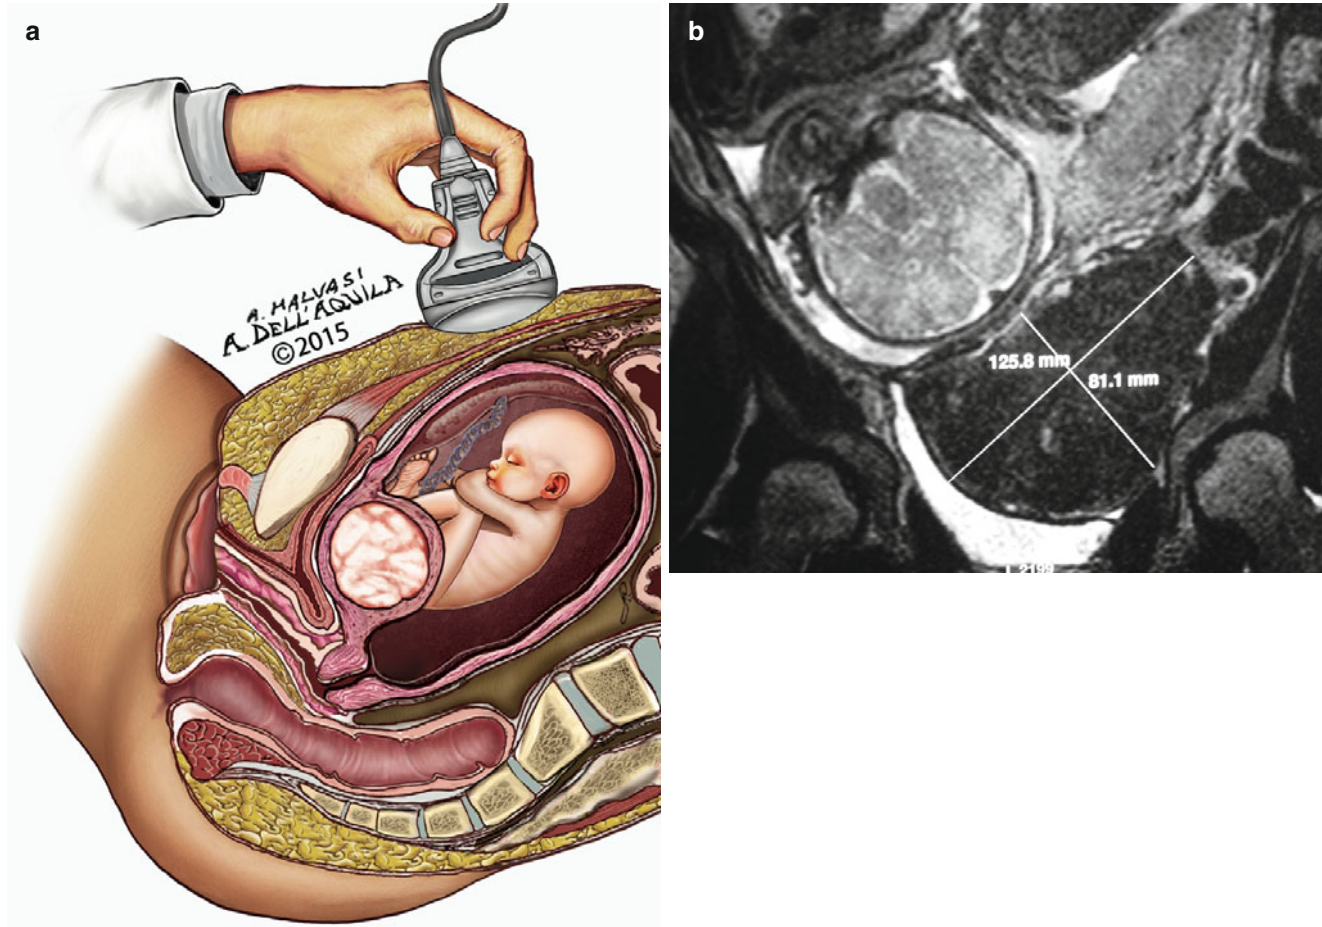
(a) A draft of ultrasonographic scan of a cervical anterior fibroid, at the beginning of pregnancy. (b) MRI image of a larger cervical fibroid obstructing the normal passageway for delivery (Courtesy of Prof. Dr. Josè Palacios de Jaraquemada)
